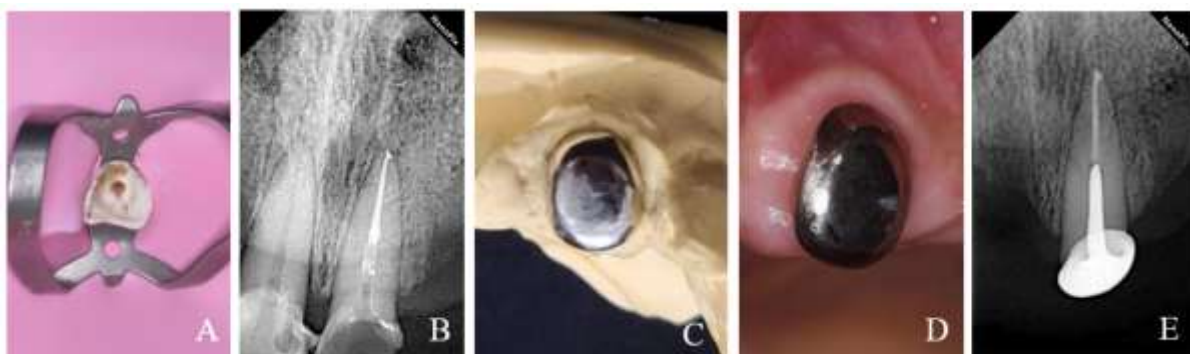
(A)Gutta-percha removal, (B)Radiograph of gutta-percha removal, (C)Metal coping, (D)Metal coping abutment insertion, (E)Radiograph of Metal coping insertion. (Source: personal documentation and patient consent for publication have been obtained)
